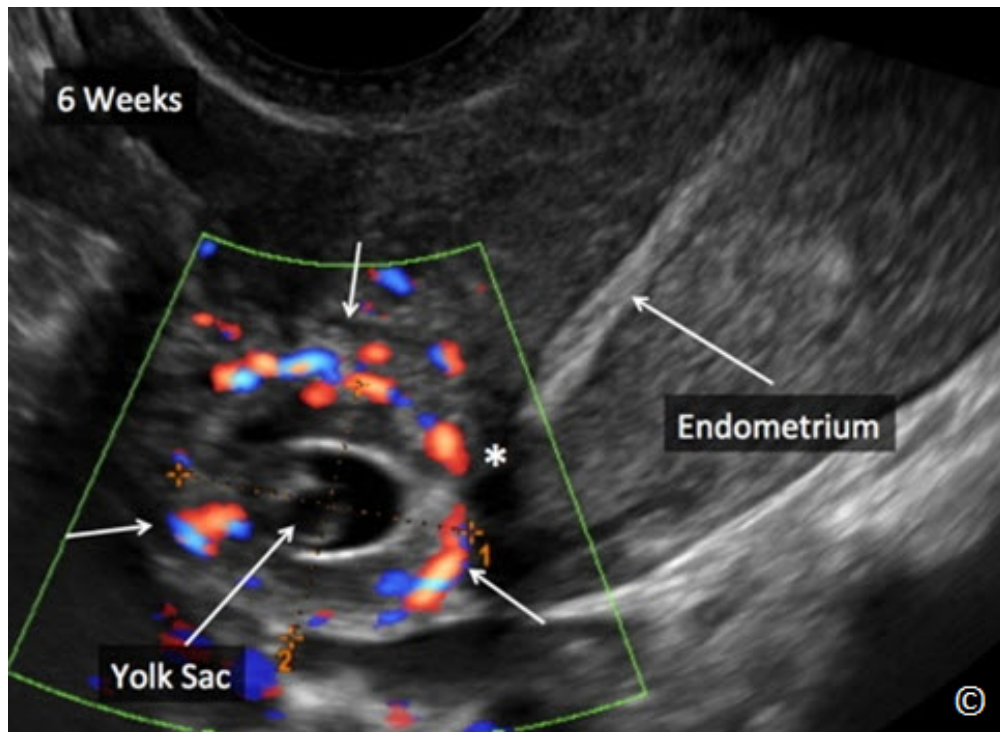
Grey scale and color Doppler ultrasound of a cornual ectopic pregnancy at 6 weeks' gestation (arrows). Note that the endometrial echo (labeled as endometrium) is distinctly separate from the cornual ectopic pregnancy (asterisk). Note the yolk sac within the ectopic pregnancy (labeled).
